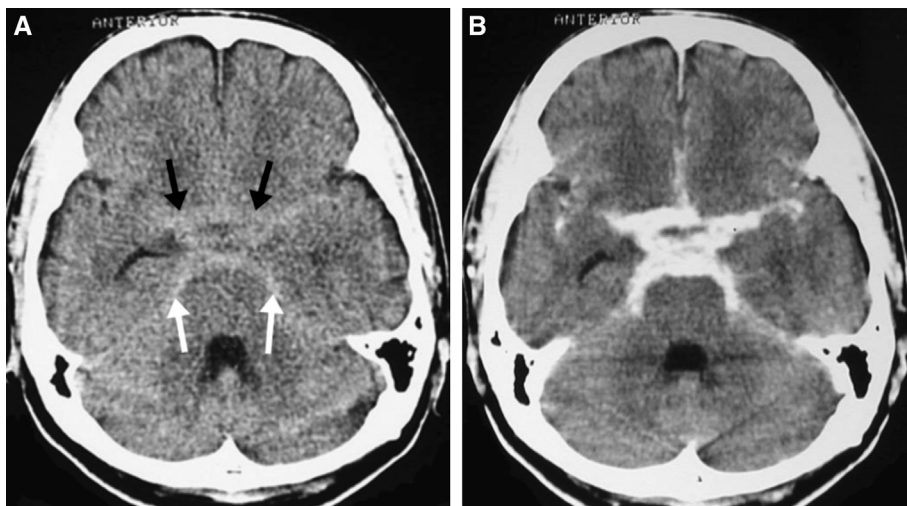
A 55-year-old man with tuberculous meningitis. (A) Precontrast computed tomography (CT), showing increased attenuation over basal cisterns (black arrows) and along the tentorium (white arrows). (B) Postcontrast CT, showing vivid enhancement in the same regions.
